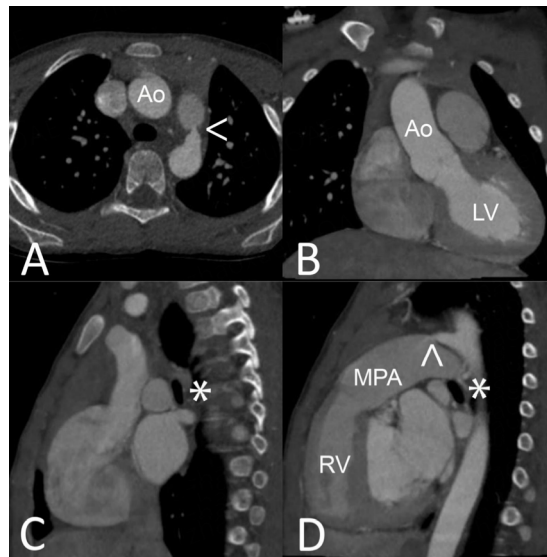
Images from a CT angiogram of the chest of the sister of the incident patient at 6 years of age. (A) An axial image showing a very small patent ductus arteriosus (arrow) as the vessel joins with the main pulmonary artery, and an enlarged ascending aorta; (B) A coronal image showing a subjectively increased mass of the LV and an enlarged Ao; (C) A sagittal image showing mild flattening of the proximal right bronchus (asterisk); (D)* A sagittal image showing a very small patent ductus arteriosus (arrow), a large MPA, subjectively increased mass of the left ventricle, subjectively normal mass of the RV, and mild flattening of the proximal left bronchus. LV: left ventricle; Ao: ascending aorta; MPA: main pulmonary artery; RV: right ventricle.
